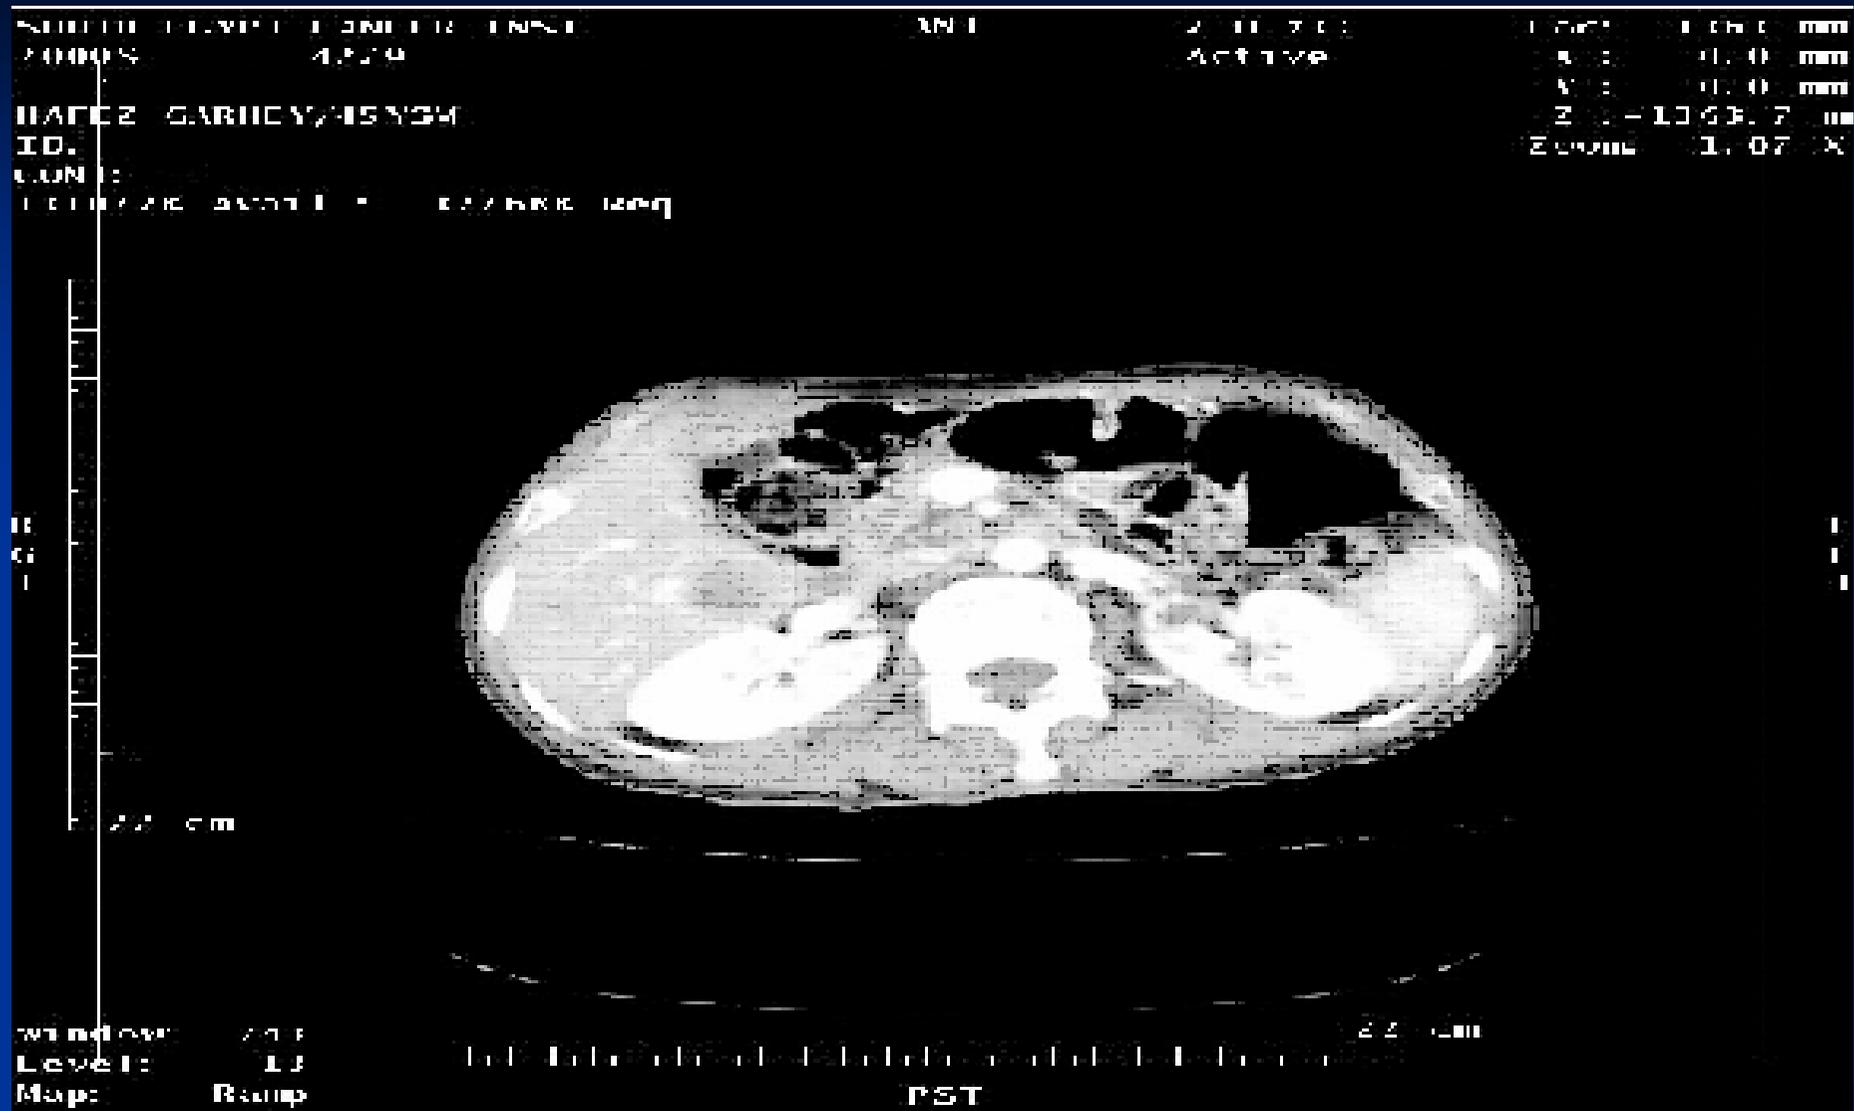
Postoperative CT showing liver metastasis after PD.
